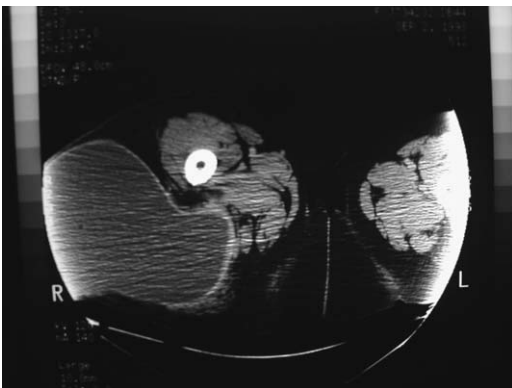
CT scan demonstrating a large Morel-Lavallee lesion. (Courtesy of Michael McKee, MD, Toronto, Canada).
